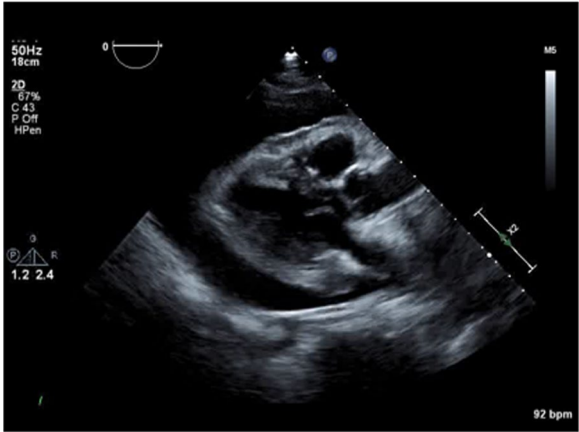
Echocardiography can show the amount of fluid around the heart in pericardial effusions
